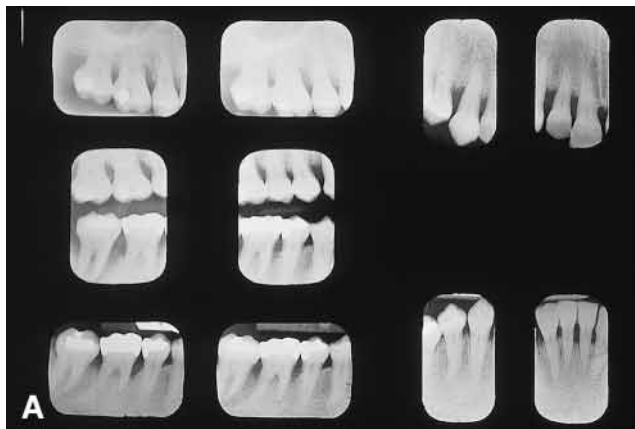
A. Clinical appearance of a 28-year-old woman diagnosed with post-juvenile periodontitis. She was infected by the putative periodontal pathogens *A. actinomycetemcomitans* and *B. forsythus*. B. Maxillary occlusal view. C. Mandibular occlusal view. D. Radiographic examination. Note extensive attachment loss, periapical periodontitis associated with mandibular left central incisor and open contacts. E. Maxillary right buccal view. Note inflammation, plaque and heavy calculus. F. Maxillary right palatal view. Note inflammation, plaque and heavy calculus. G. Maxillary anterior palatal view. Note inflammation and loss of interproximal papillae. H. Maxillary anterior buccal view. Note inflammation, egression of lateral incisor and loss of interproximal papillae. I. Mandibular anterior buccal view. Note inflammation, plaque and heavy calculus. J. Mandibular anterior lingual view. Note inflammation, plaque and heavy calculus. K. Radiographic examination of mandibular anterior quadrant.
